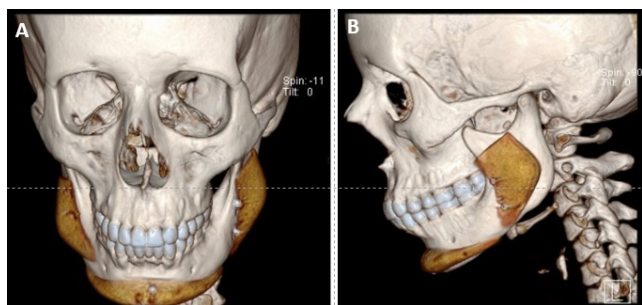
Three-dimensional cone beam computed tomogram showing a solid silicone implant placed at the mandibular angle
